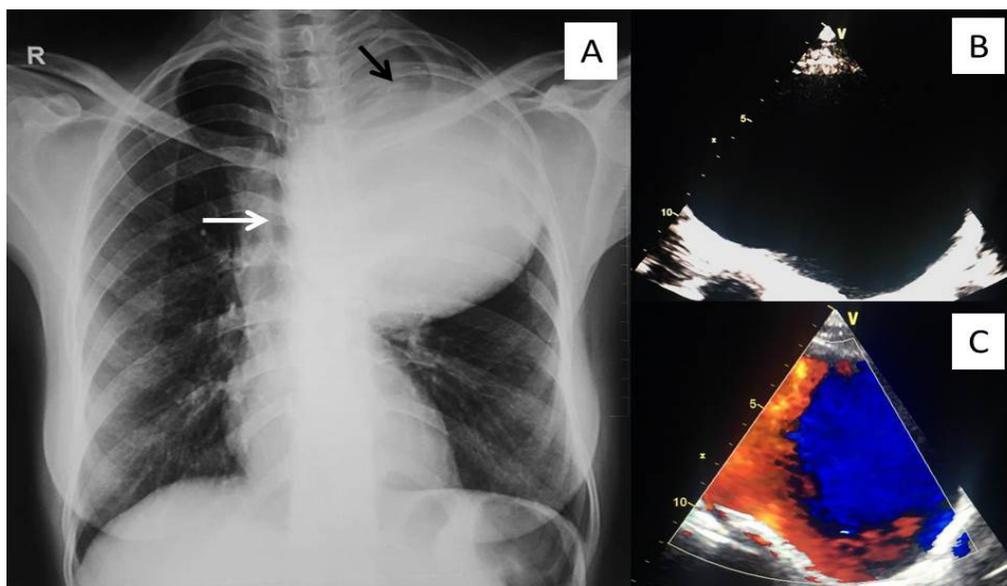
(A): Chest x-ray posteroanterior view showing a large well defined homogenous radio-opaque lesion in left upper and mid zone displacing trachea to right side (white arrow). Also note calcific foci seen along superior border of the lesion (black arrow). [B,C]: Suprasternal view on transthoracic echocardiography shows a large well defined anechoic lesion (B) with to and fro flow on color Doppler (C).
